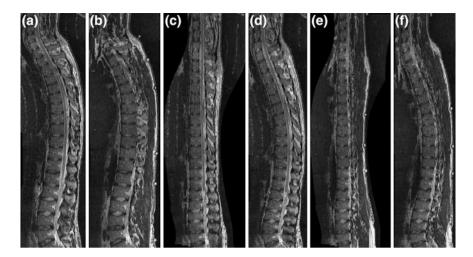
A sagittal cross-section of a 3D MR image of a normal spine, obtained by a orthogonal MPR, b oblique MPR, c orthogonal CPR (with anatomical deformations), d orthogonal CPR (without anatomical deformations), e oblique CPR (with anatomical deformations) and f oblique CPR (without anatomical deformations)
